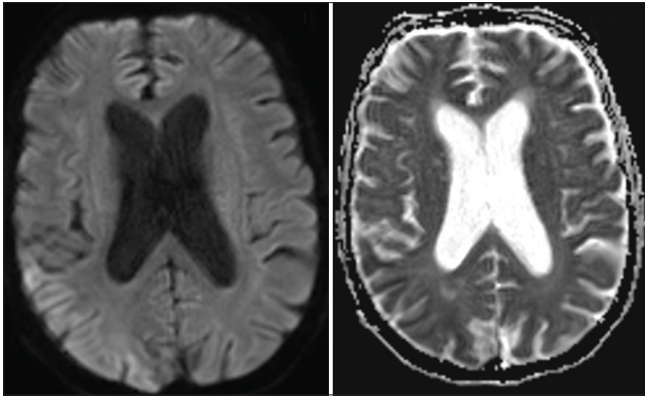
Multimodal, cerebral MRI of the presented patient shows a typical stroke-like lesion in the right occipital-temporal region, which was hyperintense on DWI and isointense on ADC
